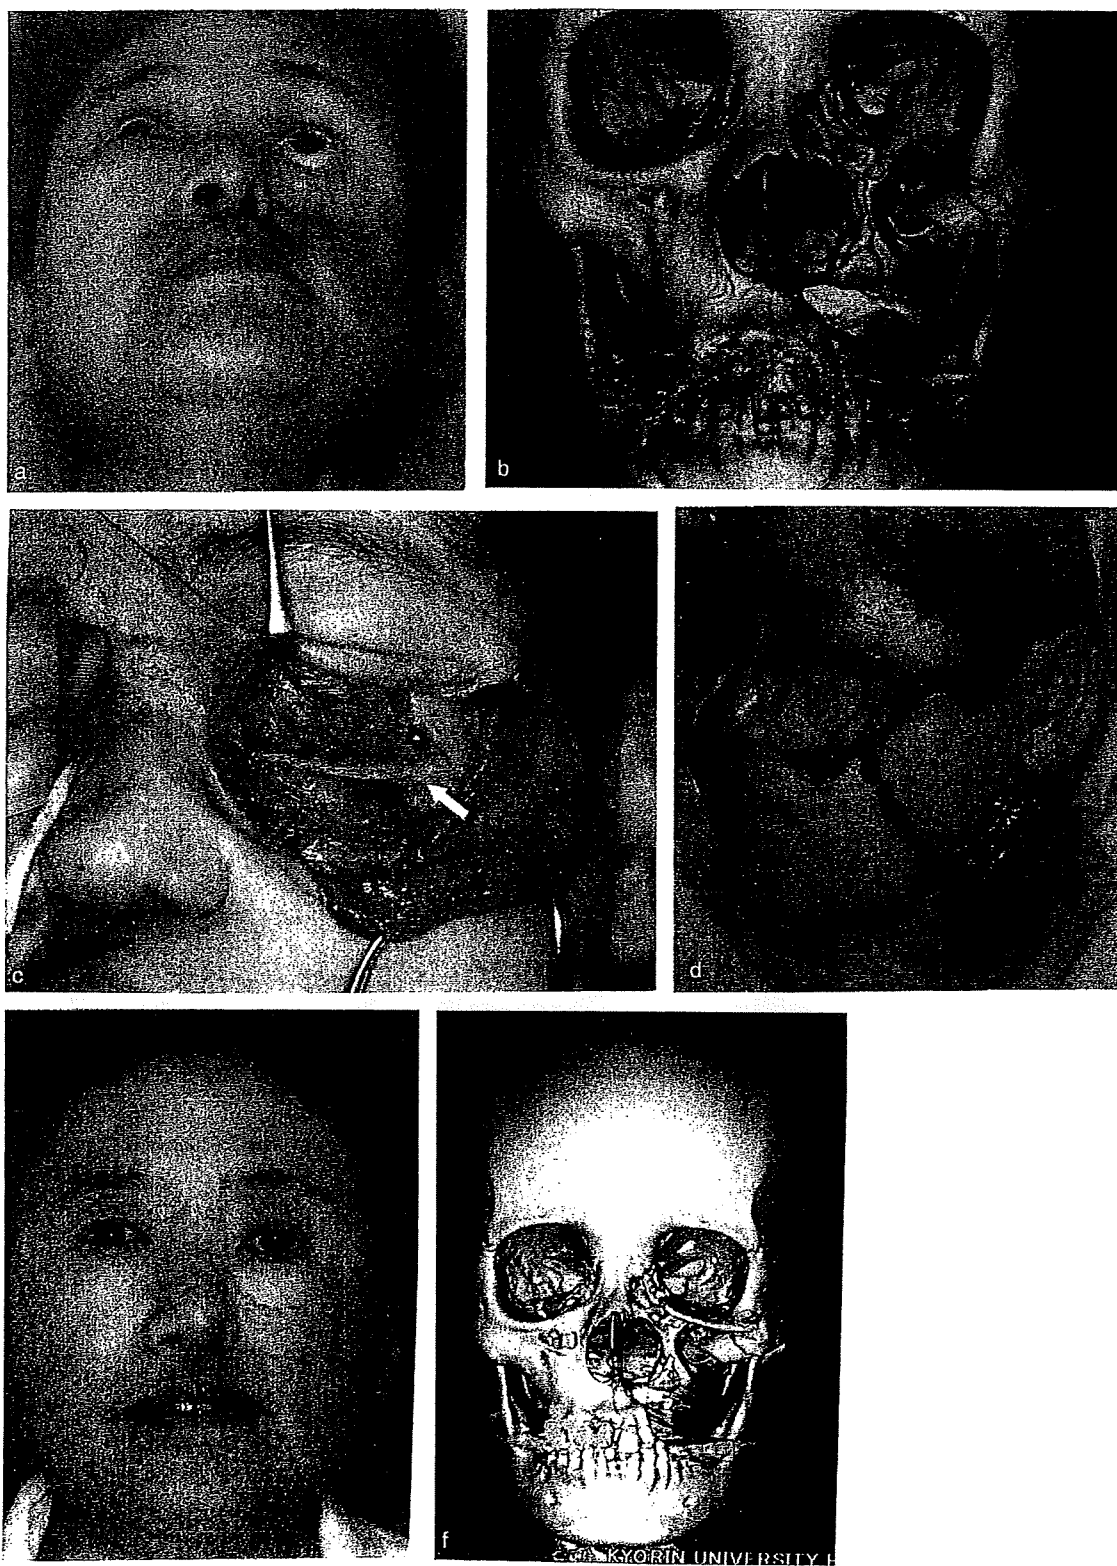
Case 2. (a) Preoperative appearance. (Published with the patient's consent). (b) Preoperative three-dimensional computed tomogram. (c) Calvarial bone (→) was used to restore the position of the eyeball. (d) An anterolateral thigh flap was used to cover the transferred calvarial bone and to reconstruct the facial skin defect. (e) Postoperative appearance at one year. (Published with the patient's consent). (f) Postoperative three-dimensional computed tomogram at one year.
